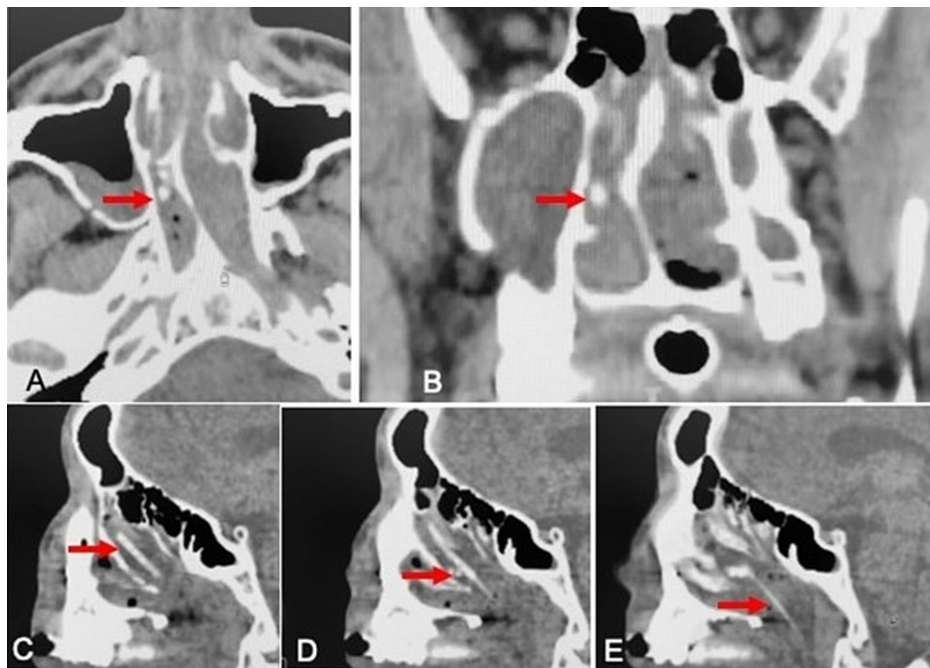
CT scan of the nose
